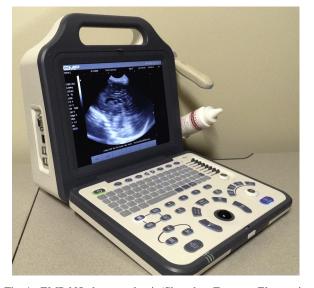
EMP-N5 ultrasound unit (Shenzhen Emperor Electronic Technology Co., Ltd.).
